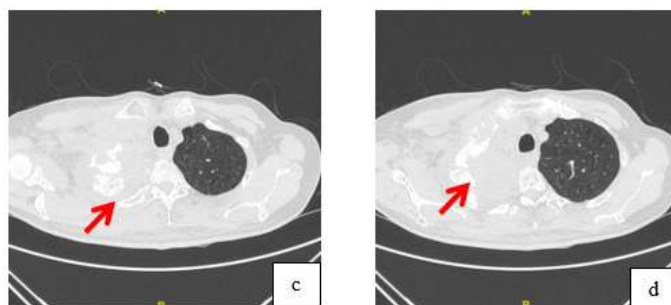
c) and d) Lung view on axial slice CT scan
